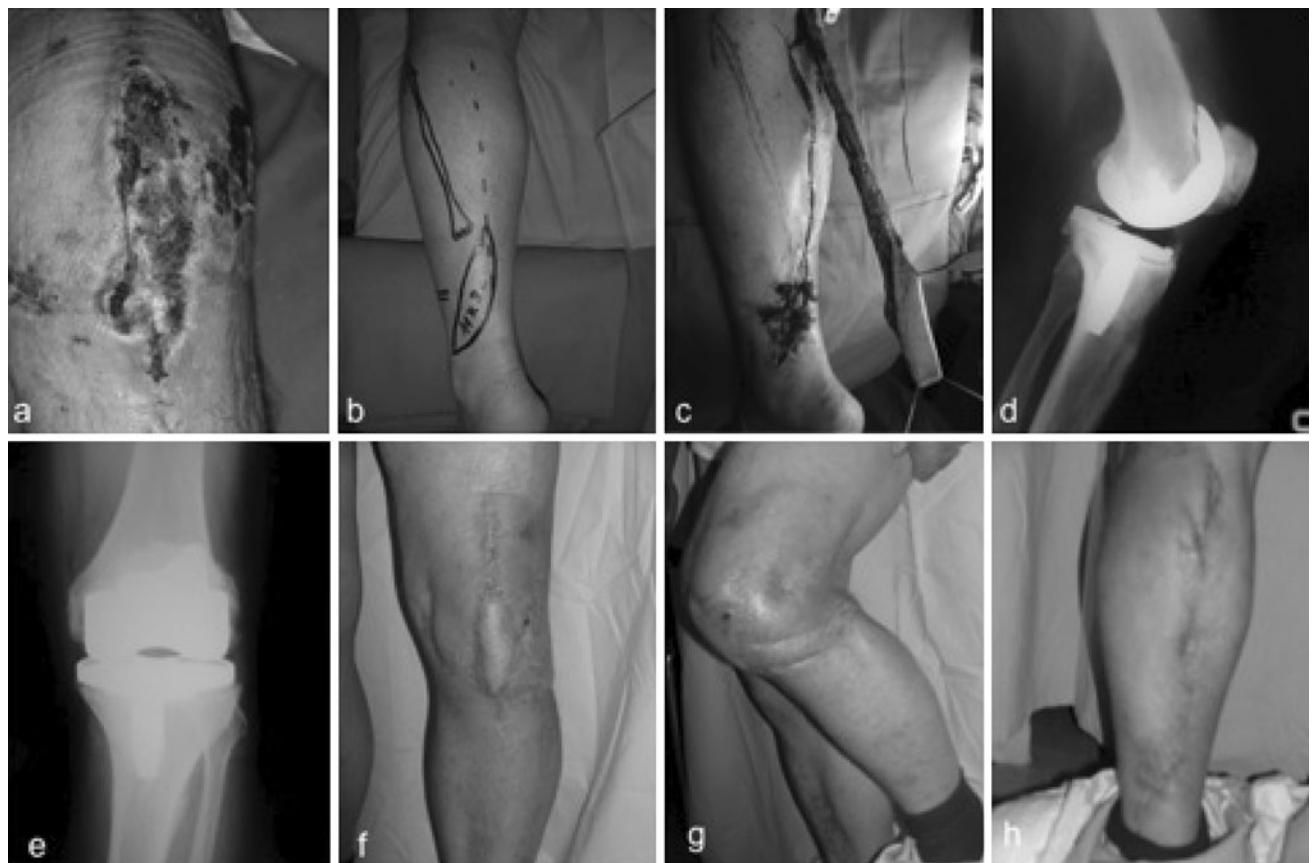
a Cutaneous necrosis. b Operation planning. c Intraoperative view: sural flap is raised and tunneled to the recipient site. d, e Radiographic view. f, g, h Postoperative views; a proximally based neuroskin sural flap provided fine and dependable soft-tissue coverage 1 year later
